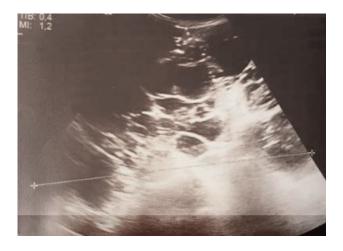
Abdominal ultrasound: Enlarged right native kidney (size>20 cm) with well-defined anechoic lesions which have thin walls, suggestive for polycystic kidney.
